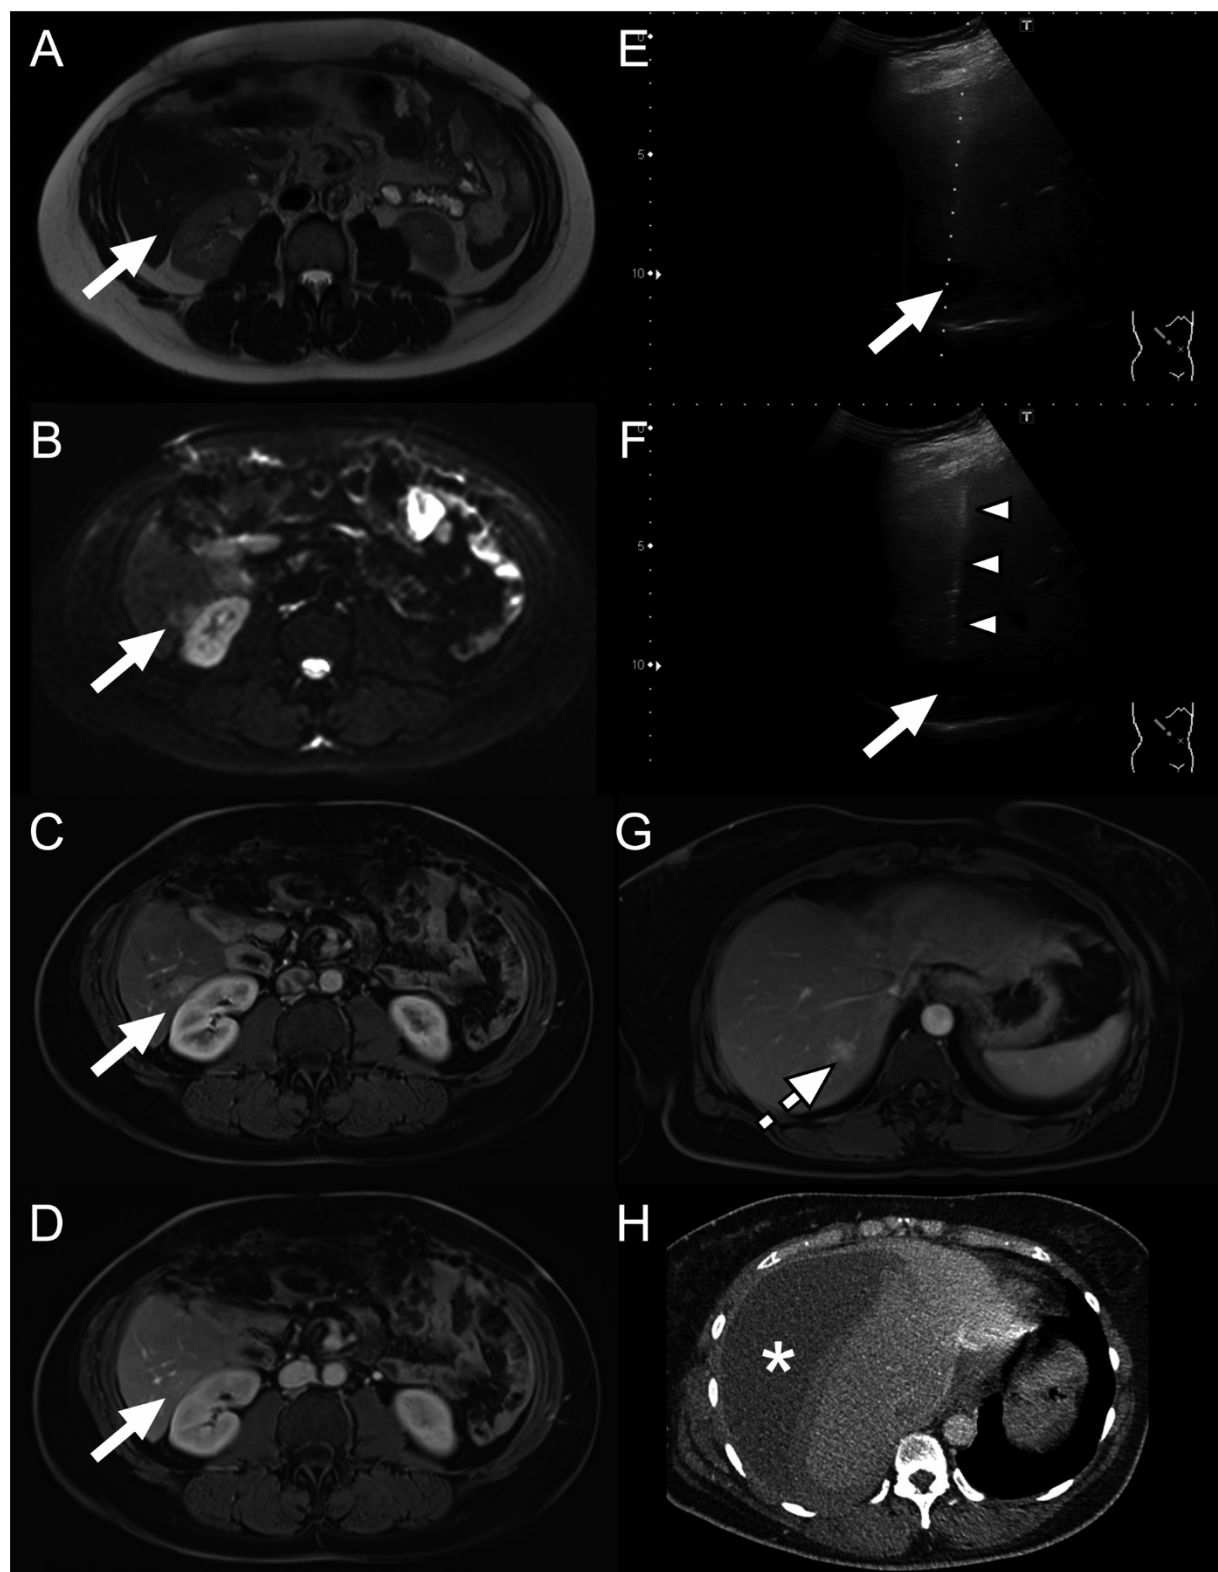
A 50-year-old woman with Von Hippel–Lindau syndrome and a history of pylorus preserving pancreaticoduodenectomy because of a grade-1 neuroendocrine tumor of the pancreatic head, underwent MRI because of recurrent episodes of pancreatitis. MRI with T2-weighted (A), low b-value (50 s/mm^2) diffusion-weighted (B), late arterial phase (C), and portal venous phase (D) MRI show a lesion in segment 6 of the liver (A–D, arrows) that was not seen on previous imaging. Because of the suspicion of metastatic disease in segment 6 of the liver, ultrasound-guided biopsy was performed. Representative ultrasonographic images show the planned biopsy path towards the lesion (E, arrow) and the biopsy needle (F, arrowheads) just in front of the lesion (F, arrow). Afterwards, it was realized that a lesion in segment 7 of the liver was erroneously biopsied, instead of the lesion in segment 6 of the liver. Portal venous phase MRI shows the erroneously biopsied lesion in segment 7 of the liver (G, dashed arrow) that was unchanged compared to previous imaging and that was thought to represent a hemangioma (pathology revealed focal nodal hyperplasia). Directly after biopsy, the patient developed a large subcapsular hematoma that required blood transfusion. The subcapsular hematoma became infected and was surgically treated. Because of the post-biopsy complications, the patient was hospitalized for 16 days, including 10 days intensive care admission.
